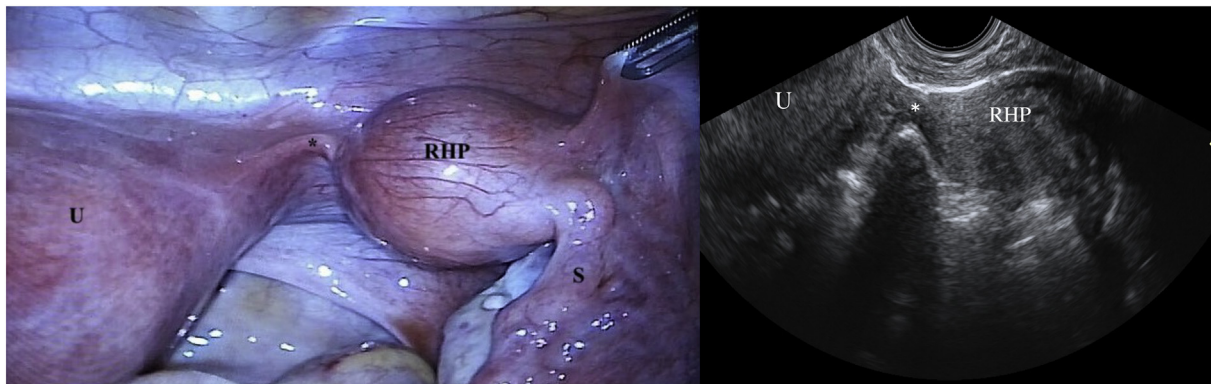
Laparoscopic (a) and ultrasonographic (b) view of right rudimentary horn containing pregnancy. Asterisk (*) indicates the fibrotic band connecting uterus to the rudimentary horn. U uterus, RHP rudimentary horn pregnancy, S salpinx.
